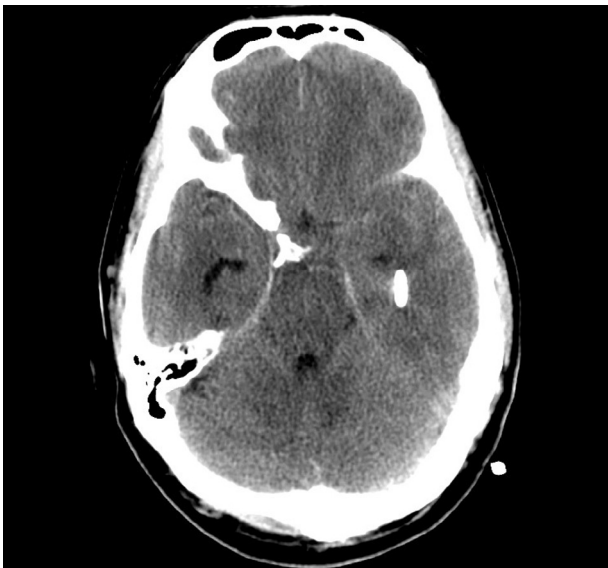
Axial unenhanced CT scan of the same patient in Figure 1 after placement of a bedside external ventricular catheter utilizing electromagnetic neuronavigation.
